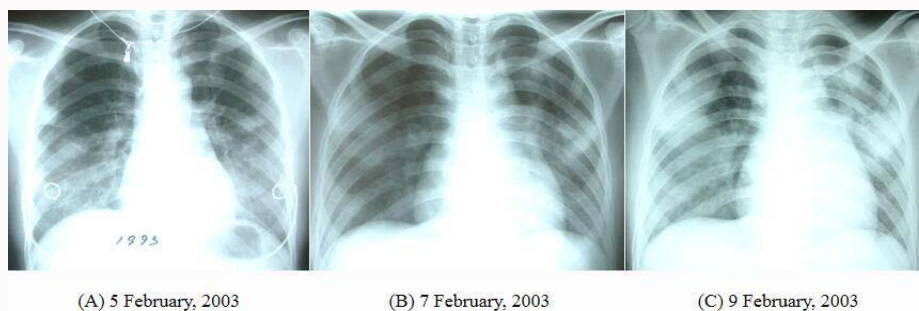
The deterioration of pulmonary lesions on chest X-ray. A) Chest X-ray showed a circular infiltrating shadow in the middle and lower lobe of right lung. B) The lung lesions in bilateral lungs disappeared but a new round ground glass opacity with hazy border appeared in lingual lobe of left lung. C) The infiltrating shadow with high density in the lingual lobe of left lung and the upper lobe of right lung enlarged and patchy opacity appeared in bilateral lower lungs.
